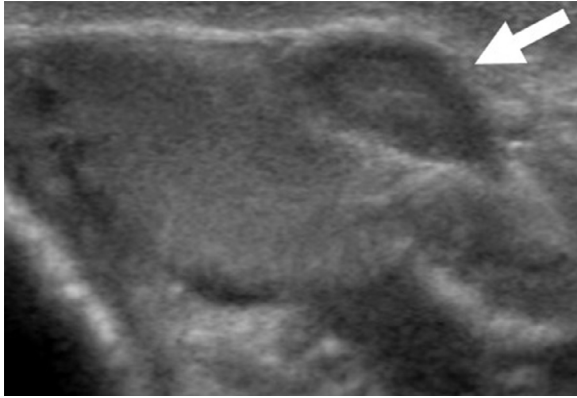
Axial grayscale ultrasound image of the right testicle. Well defined hypoechoic extra-testicular mass adjacent to the right testicle (arrow), seen 6 years previous.
